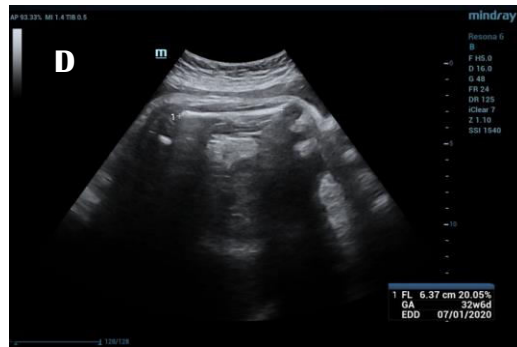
32 year-old pregnant female (GA 33+5 by scan, 30+2 by LMP) diagnosed GDM with no history of any medical disorders, came to our hospital for routine obstetric examination RBS=145, HBA1C= 7, MCA PI =2.5, MCA PSV=54.74 cm/sec, mild fetal macrosomia by ultrasound fetal weight by ultrasound =2510 Kg, outcome: cesarean section at 38 weeks GA, macrosomic baby with birth weight 4.3 Kg 1 day-NICU admission to stabilize respiration. No maternal complications.(A&B) show Doppler waveforms of MCA and UA, (C) shows femur length with corresponding gestational age 32+6 days.
